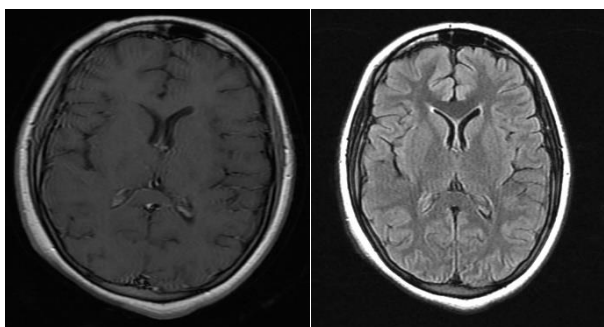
MRI brain Flare and contrast enhanced sequence showing no abnormality
